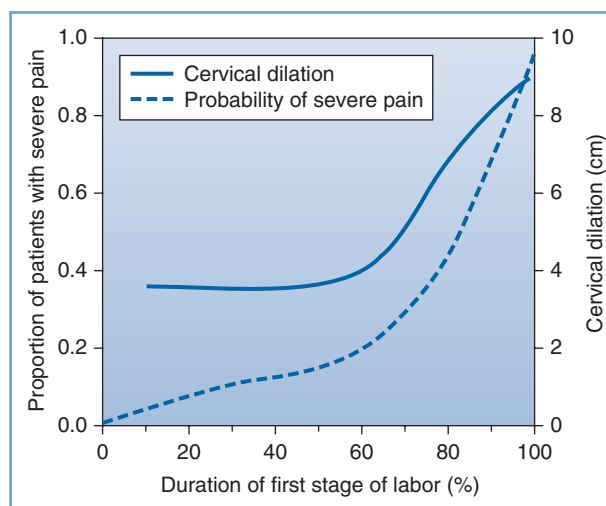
■ Likelihood of severe pain during labor. A significant minority of women (approximately one third) have severe pain in early labor, and the proportion of women with severe pain increases to nearly 90% later in labor, in close relationship with cervical dilation. (Data adapted from Hardy JD, Javert CT. Studies on pain: measurements of pain intensity in childbirth. *J Clin Invest* 1949; 28:153-62.)
